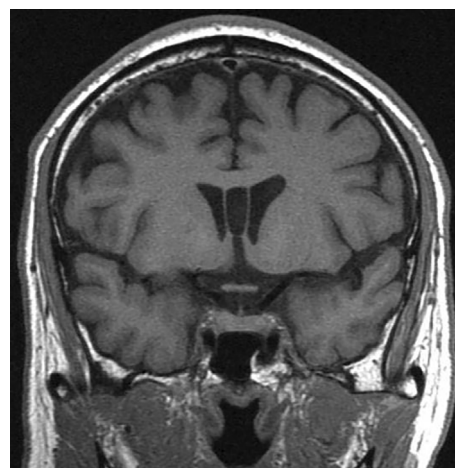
Coronal T1-weighted magnetic resonance imaging (MRI) of the pituitary gland. MRI shows no enlargement of the pituitary gland or thickening of the pituitary stalk.
